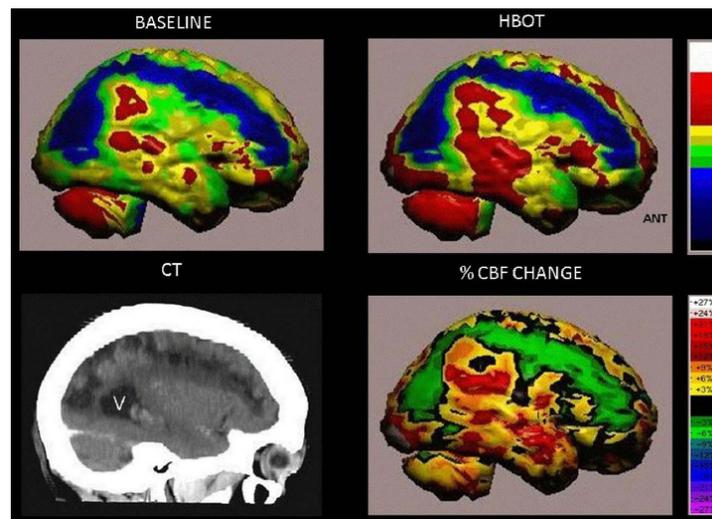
SPECT (the colored pictures) and CT (the B&W picture) of a patient suffering from left hemiparesis due to ischemic stroke that occurred 26 months prior to treatment. The upper two images show the infarcted brain (deep blue color) involving the right antero-postero-lateral frontal, right superior-parietal and right parieto-occipital regions. Curved sagittal view in CT (bottom left) shows the anatomical stroke area (V = posterior horn of right ventricle). The peri-infarct region shows improved perfusion as demonstrated by SPECT image (right upper image). Quantitation of the cerebral blood flow (CBF) change (before and after treatment) is demonstrated in the right lower image. (Courtesy of Dr. Efrati)
